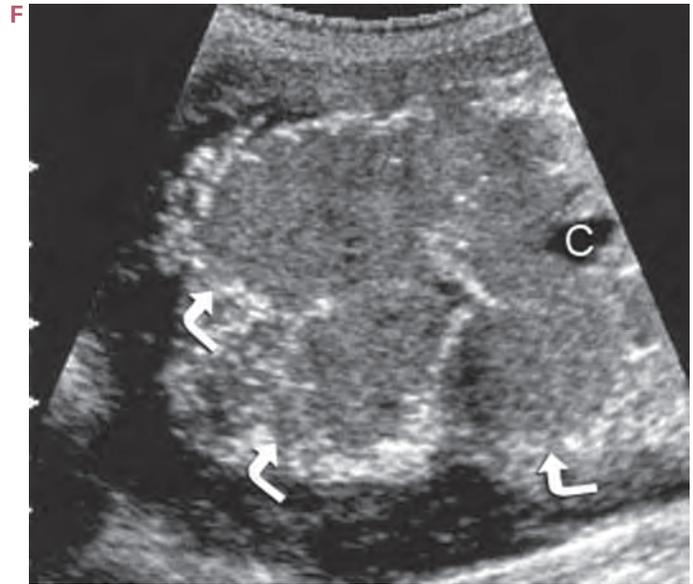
A Grannum's placental grading starts with grade 0 (late first to early second trimester), with a smooth echo pattern of the parenchyma, no calcifications of the chorionic/basal plate, and no indentations of the chorionic plate. Grade I (mid-second to early third trimester) displays diffuse, randomly distributed calcifications (2–4 mm) and subtle indentations of the chorionic plate. Grade II (late third trimester to delivery) is characterized by dot-dash calcifications parallel to the basal plate and larger indentations of the chorionic plate. Finally, grade III (39 weeks to postdelivery) displays larger calcifications and indentations of the basal plate. Reprinted with permission from Grannum PA, Berkowitz RL, Hobbins JC: The ultrasonic changes in the maturing placenta and their relation to fetal pulmonic maturity. *Am J Obstet Gynecol* 133:915, 1979. B Anterior grade 0 placenta showing smooth homogeneous echo pattern and smooth chorionic plate. C This posterior grade I placenta demonstrates undulation of the chorionic plate, making it appear broken, and there is mild heterogeneity of the placenta. D This anterior placenta shows bright echogenic foci scattered throughout the placenta and especially along the basal area (arrows), typical of grade II. (Figure continues . . .)
